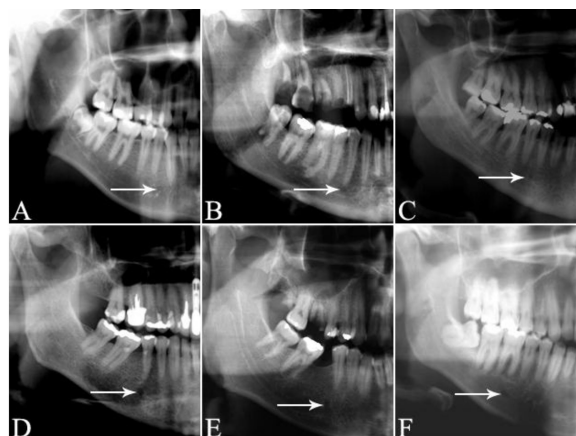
Radiographic findings on the position of the mental foramen according to the classification of Tebo and Telford. A: class I; B: class II; C: class III; D: class IV; E: class V; F: class VI.
